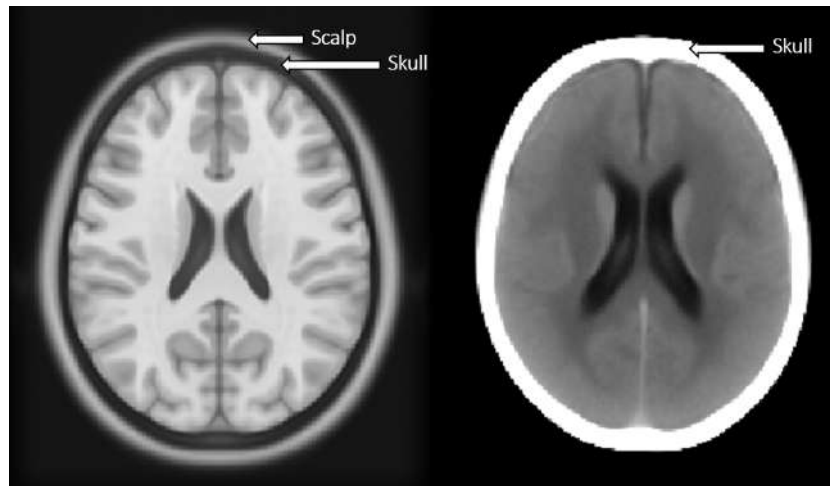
Structural differences between brain edges in MRI and CT. While on CT the higher intensity external layer corresponds to the skull, on MR it is comprised of mostly scalp tissue.
